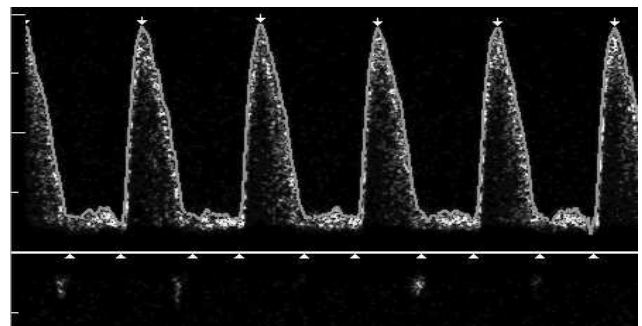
The Doppler waveform in vasoconstriction
